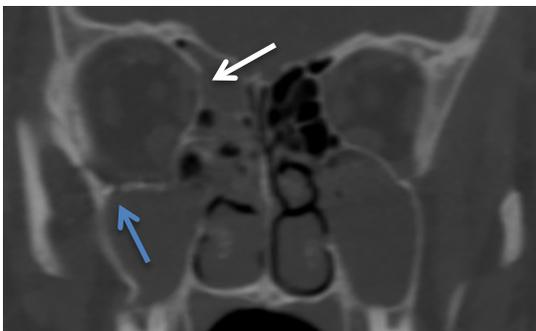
Le Fort 2°, right eye (15-year-old adolescent without clinical limitations). CT, coronal section: Fracture of the medial wall (white arrow) and orbital floor (blue arrow).
